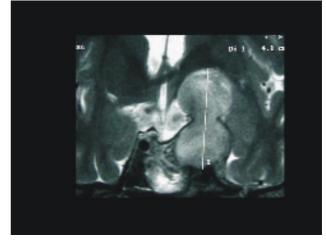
T2-weighted coronal image shows a Grade III pituitary tumor with unilateral cavernous sinus invasion. B. Post-operative T2-weighted coronal image shows complete excision of the midline tumor. Residual tumor is noted in the cavernous sinus.
